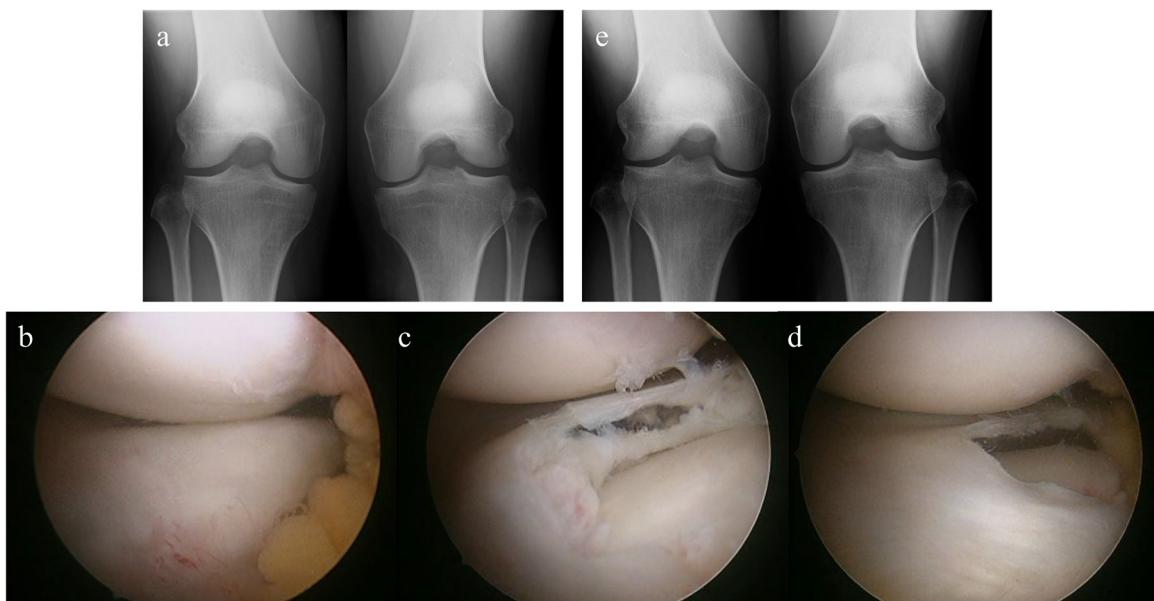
Images of the second case. Preoperative Rosenberg-view radiograph of bilateral knees (a). Intraoperative arthroscopic images; no tear on the femoral side of the discoid lateral meniscus (b), horizontal tear throughout its body (c), and about half of the width of the remaining stable leaf is preserved (d). Postoperative Rosenberg-view (e) at 2 years after surgery.
